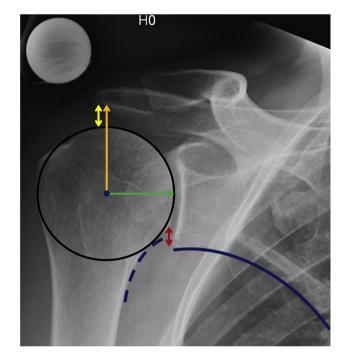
Anteroposterior shoulder radiograph in a patient with AC demonstrating the disruption of the glenohumeral arch (dashed blue line), the AHI (yellow double arrow), the IGHD (red double arrow) in a patient with AC. The UMI was defined as the distance between the lowest point of the acromion and the *Center* of the humeral head (orange arrow), divided by the radius of the humeral head (green arrow). AC, adhesive capsulitis; *AHI*, acromiohumeral interval; *IGHD*, inferior glenohumeral distance; *UMI*, upward migration index.
